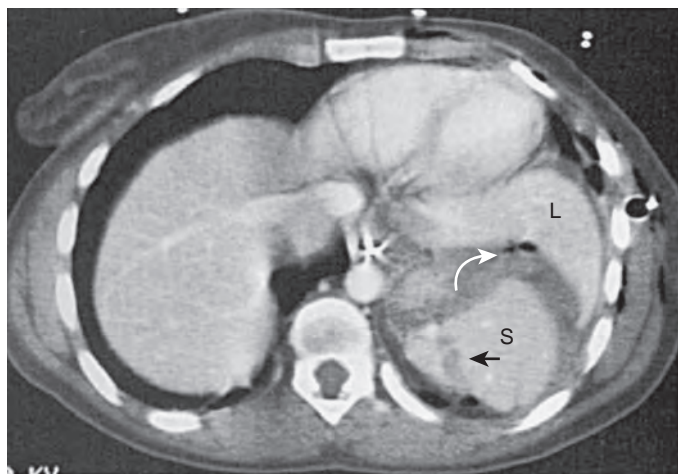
Penetrating splenic injury. CT scan of a 22-year-old woman who was stabbed in the anterior chest shows a low-attenuation splenic laceration (black arrow) and gas bubbles (curved white arrow) from gastric perforation. The prominent left hepatic lobe (L) is a variant that can abut the lateral margin of the spleen (S).
